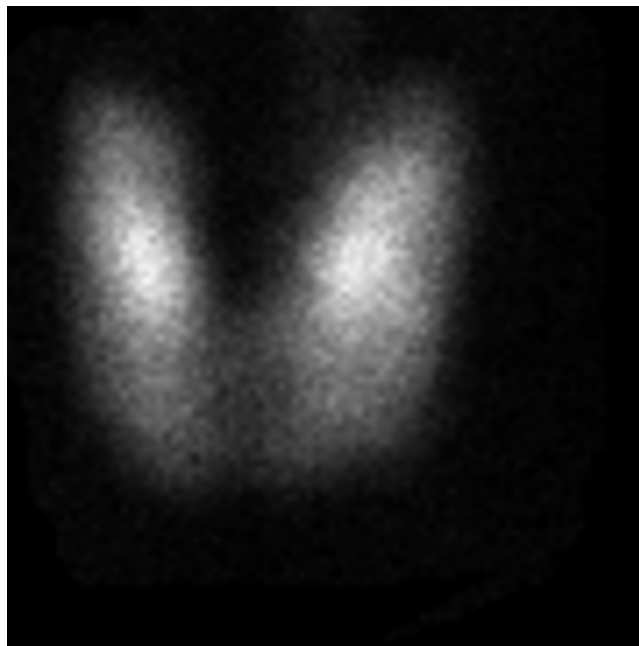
Demonstration of scintigraphic diffuse nonhomogenous uptake image
